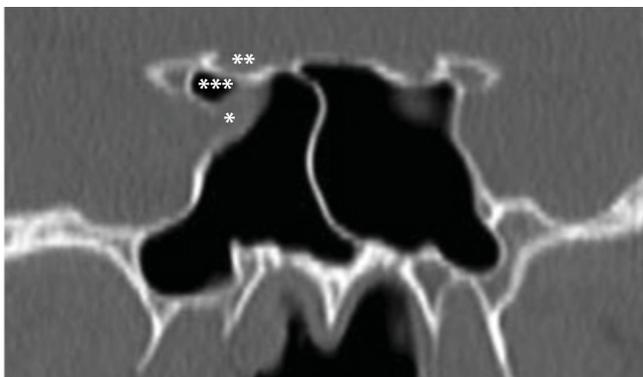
Coronal CT cut through sphenoid sinuses. Internal carotid artery (*), optic nerve () and optico-carotid recess (*).
